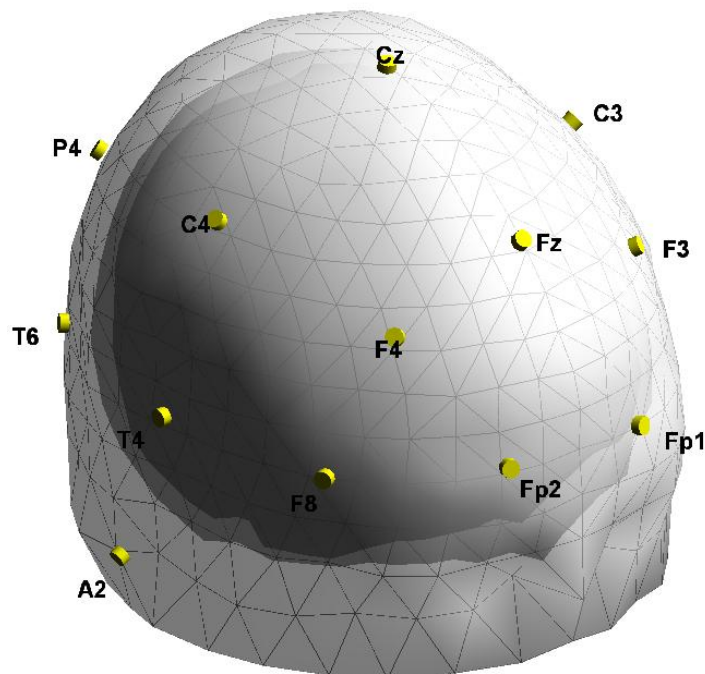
Standard head model as used for 3D source localization for all patients in this study. The model is constructed by segmentation of the Colin 27 MRI dataset and consists of a brain, skull and scalp volume. Electrode locations are situated on the surface of the scalp volume.
